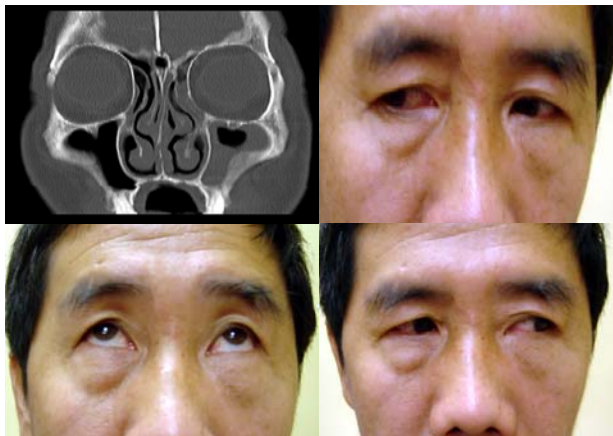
(clockwise from top left): CT scan of left orbit showing mineralization of implant after 1 year, 3 views of patient moving eyes in various directions without hindrance
